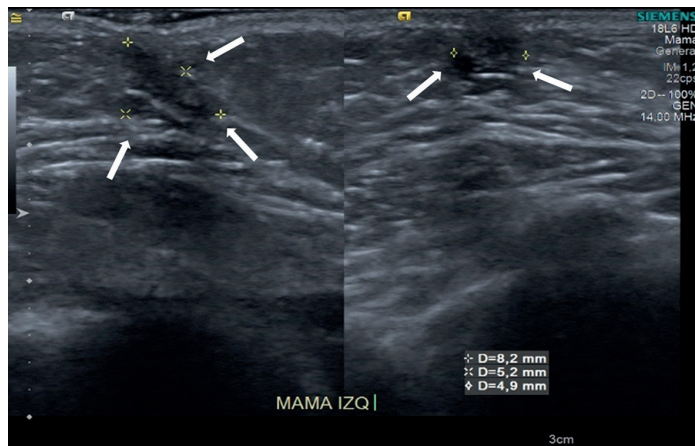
Left breast ultrasound showed a diffuse hypoechoic retroareolar fibroglandular tissue, poorly vascularized, measuring 8 × 5 × 5 mm.
